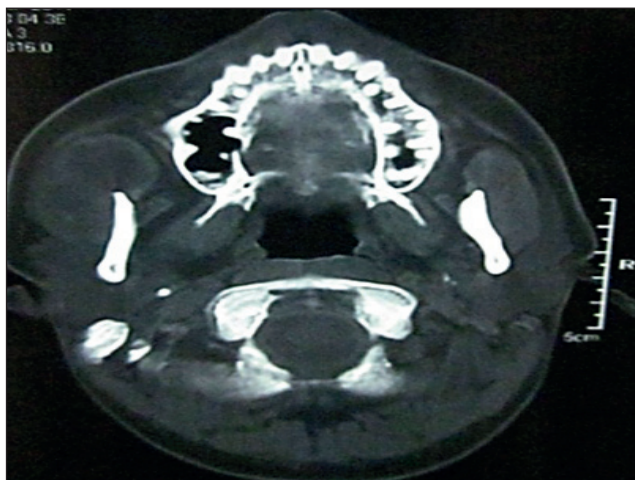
CT scan showing well localized abscess lateral to the ramus of mandible, beneath the right zygoma.
